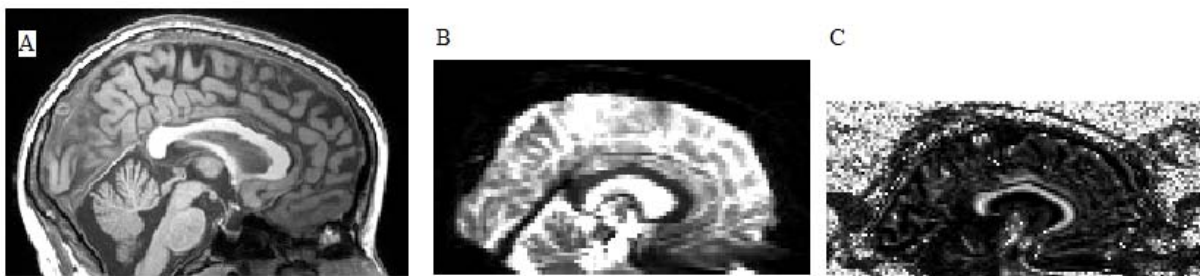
Example of an MRI image, T_1 -weighted image (a), an DWI image acquired with a b value of $0 \text{ s}^2/\text{mm}$ (b) and a pixel-by-pixel FA map (c). All images are from the same MS patient.
